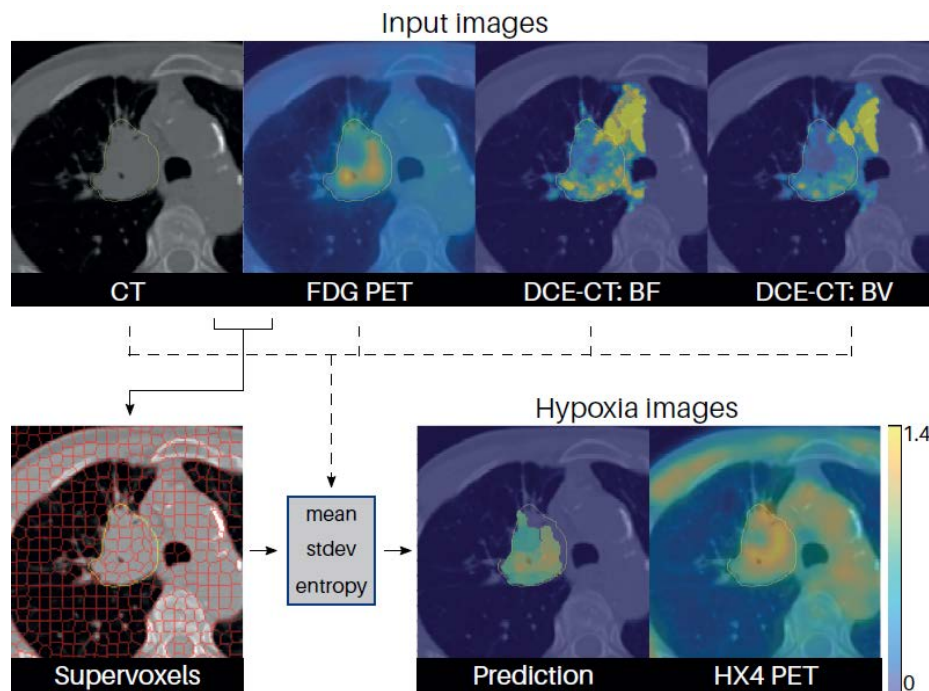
Classification of tumour hypoxia for patient stratification with CT, FDG PET, and DCE-CT in lung tumours.
